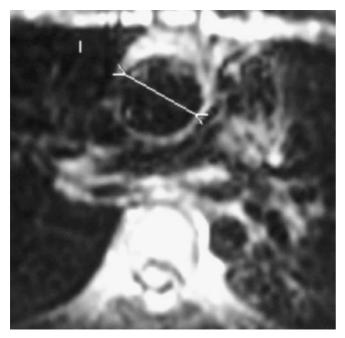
Axial T1-weighted MRI showing proximal ascending aortic ectasia
